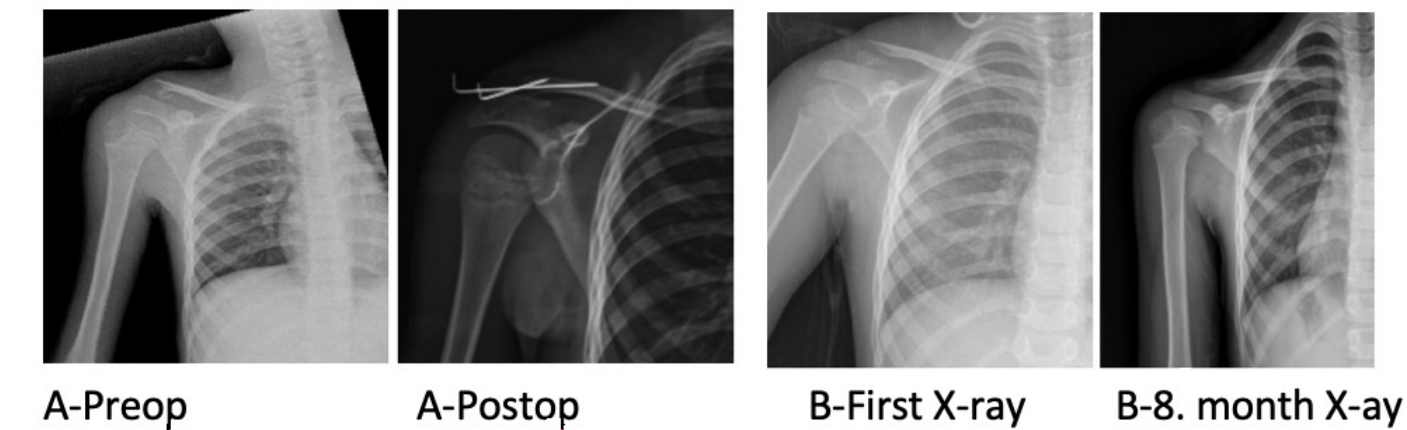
Representative radiographs of pediatric lateral clavicle fractures. (A) Surgically treated case demonstrating fixation method and postoperative alignment. (B) Conservatively treated case showing typical fracture appearance and follow-up healing
